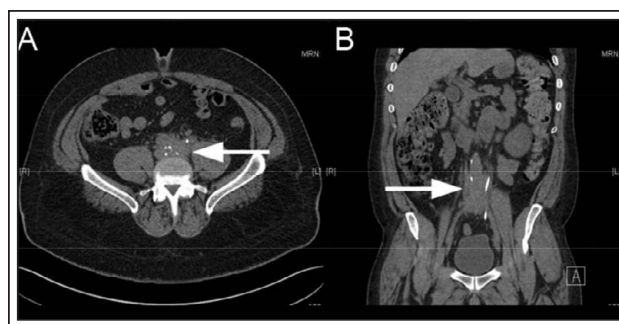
CT abdomen/pelvis without contrast. Retroperitoneal fibrosis at the level of the aortic bifurcation with encasement of both ureters. (A) Axial section demonstrating encasement of left ureter, with double-j stent in place. (B) Coronal section demonstrating encasement of right distal ureter with proximal hydroureteronephrosis. Hydroureteronephrosis demonstrated bilaterally.
